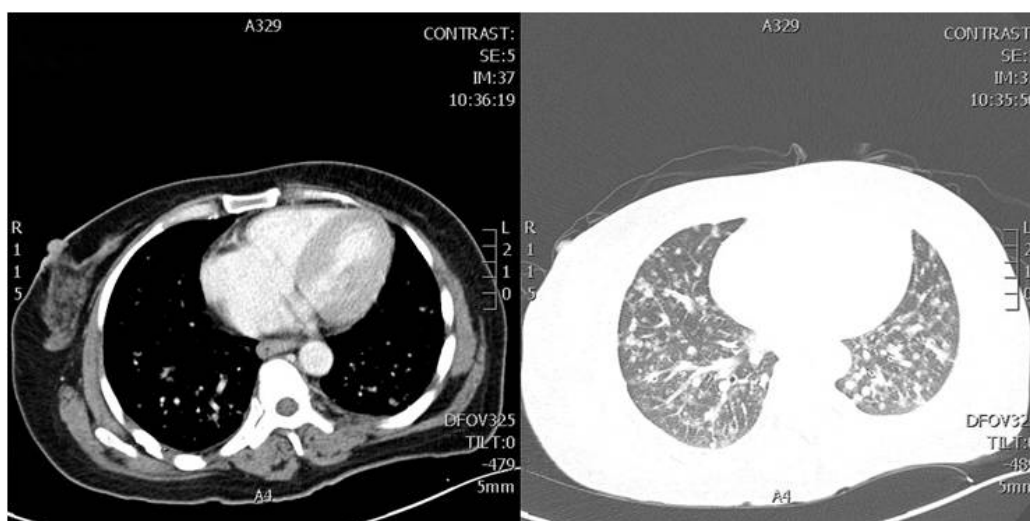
Enhanced computed tomography (CT) scan of the chest
